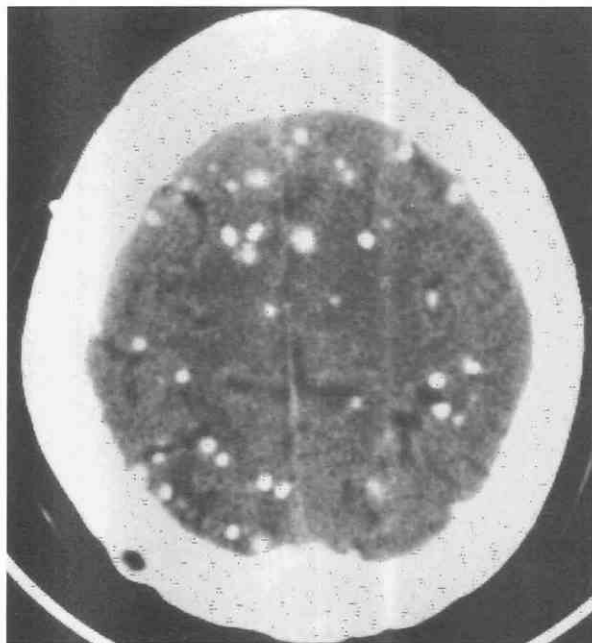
Cysticercosis. Noncontrast CT scan reveals multiple intracranial calcifications, consistent with dead larvae.
